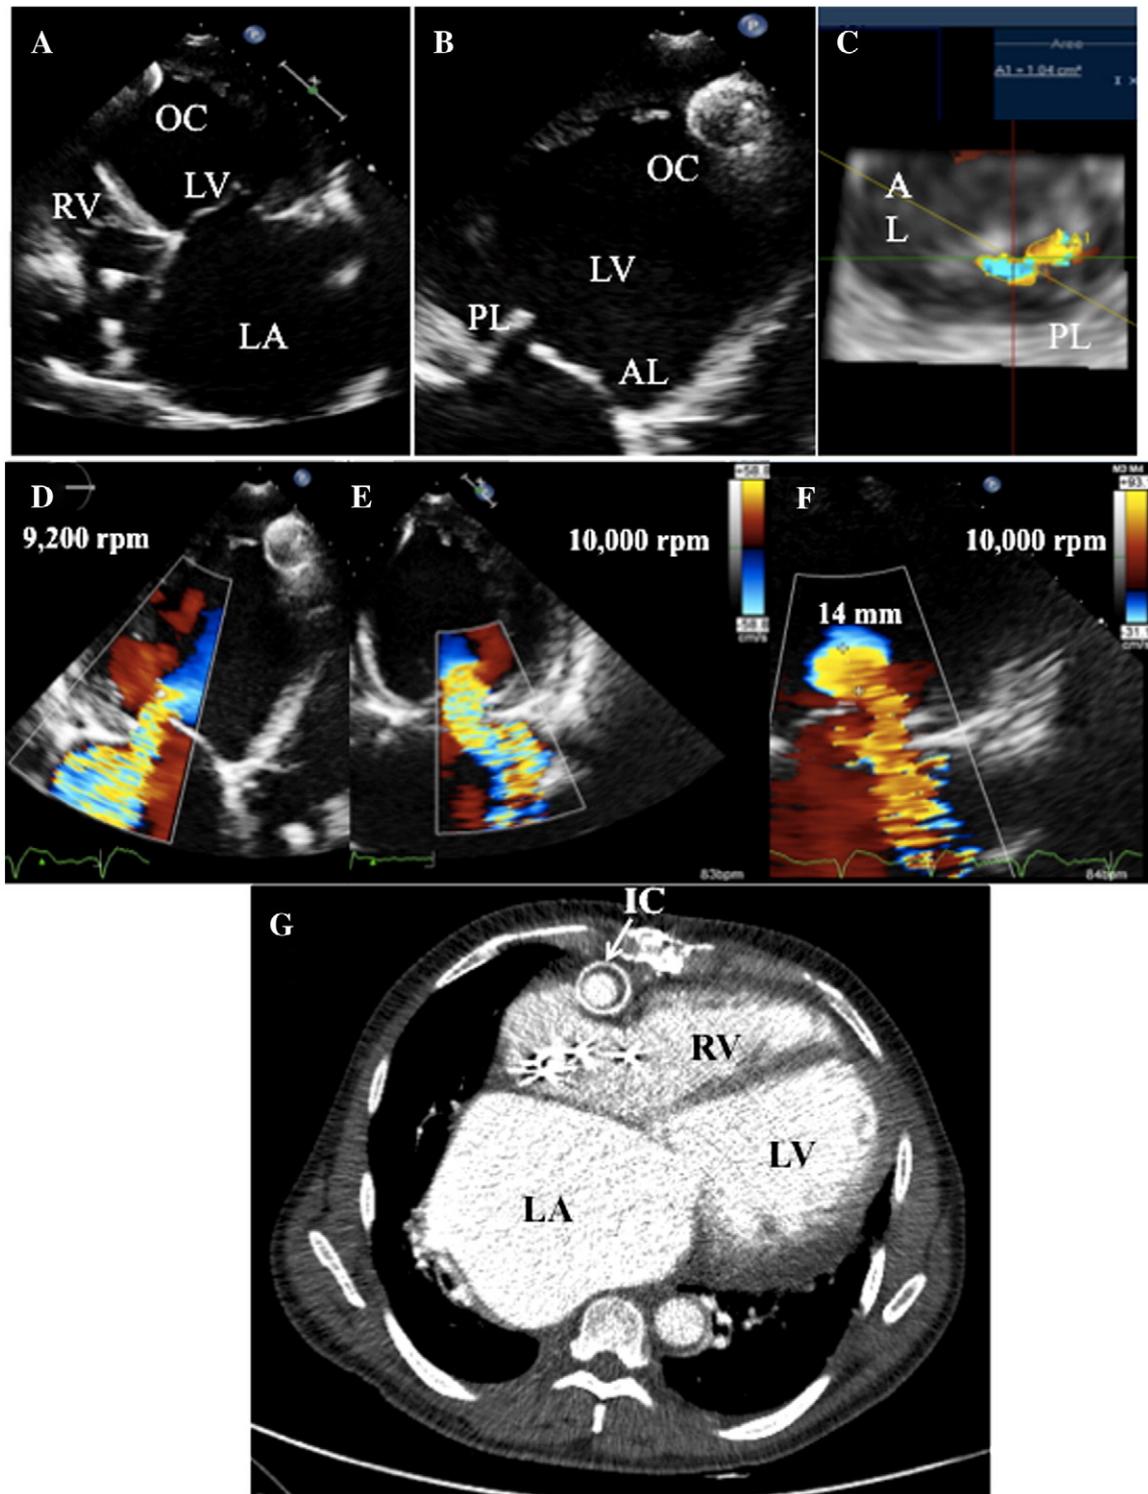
Echocardiographic assessment after left ventricular assist device (LVAD) implantation: (A) the apical 4-chamber view showed persistently increased dimensions of the left ventricle (LV) and of the left atrium (LA) with mildly dilated right ventricle (RV). (B) The apical 3-chamber view showed the “fixed” posterior leaflet (PL) motion associated with anterior leaflet (AL) pseudoprolapse secondary to papillary displacement and annular dilatation (antero-posterior diameter 39 mm). (C) 3D image that shows the regurgitant orifice area (1.04 cm²) of the mitral valve. The outflow cannula (OC) was correctly positioned in the middle of the LV, excluding technical problem as possible cause of unsatisfactory LV unloading. Color Doppler images of the severe mitral regurgitation (MR) at LVAD speed of 9200 rpm (D), which remained unchanged at LVAD speed of 10,000 rpm (E). Quantification of the MR through the calculation of effective regurgitant orifice area (EROA) by the proximal isovelocity surface area (PISA) method showed a regurgitant volume of 106 ml at LVAD of 10,000 rpm (F). (G) Computerized tomography scan with contrast agent of the chest of the patient after 5 months since the implant showed extremely dilated left ventricular chambers. IC = inflow cannula of the left ventricular assist device. Artifacts and poor quality of the image are due to the presence of the device.
